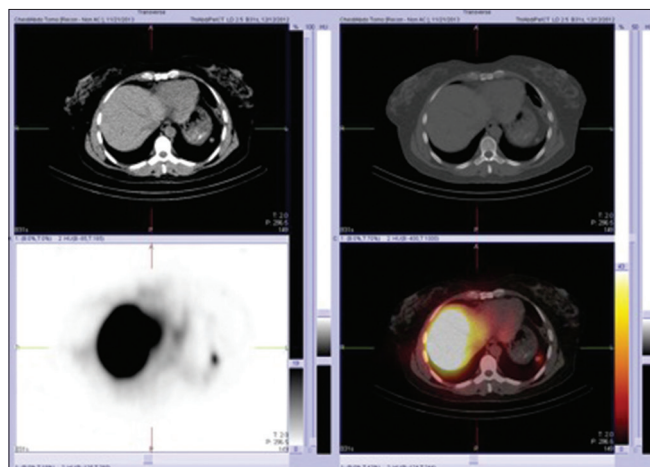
Spleen scan using heat damaged red blood cell labeled with ^{99m}Tc in patient known with autoimmune hemolytic anemia (Evan's syndrome). The patient had splenectomy. Single-photon emission computed tomography image (lower left) showed a focal area of ^{99m}Tc-red blood cell uptake which was localized by the fused single-photon emission computed tomography-computed tomography to a residual splenic tissue in the splenic bed posterolateral to the splenic flexure of the colon consistent with splenunculi
